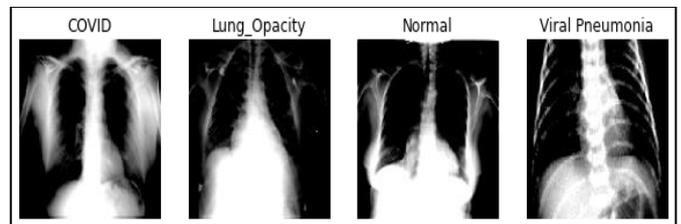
Sample of X-Ray dataset
